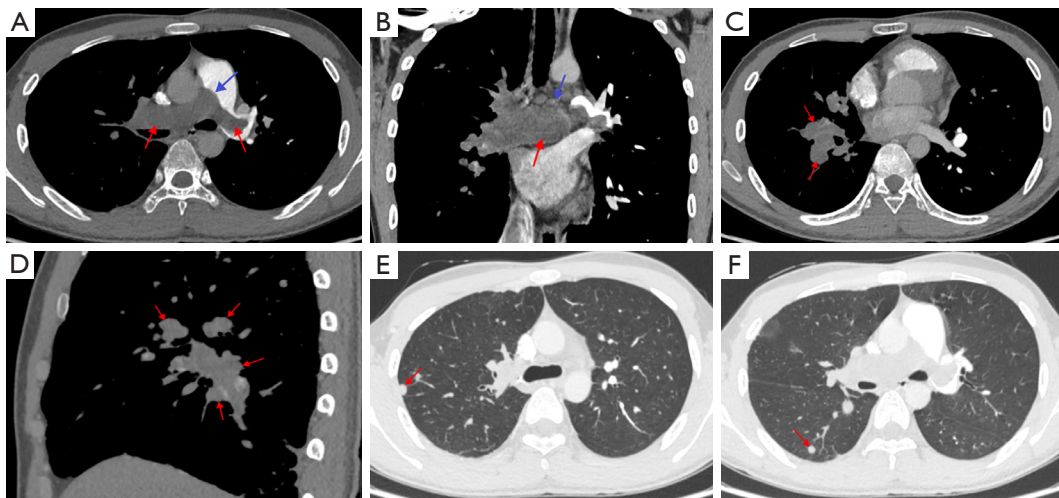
A 19-year-old man with a pathological diagnosis of pulmonary artery sarcoma. (A) CTPA axial image showed filling defects located in the main and bilateral pulmonary arteries (red arrows), with a bulging proximal margin of the lesion (blue arrow). (B) CTPA coronal imaging showed that a mass had grown expansively in the right pulmonary artery (red arrow), occupying the entire lumen and eclipsing the pulmonary artery wall (wall-eclipsing sign) (blue arrow). (C,D) CTPA axial and sagittal images showed that the lesion was filling the right middle and lower lobe pulmonary arteries along its course giving it a grape-like sign (red arrows). (E,F) Multiple metastatic tumors in the right lung (red arrows). CTPA, computed tomography pulmonary angiography.
